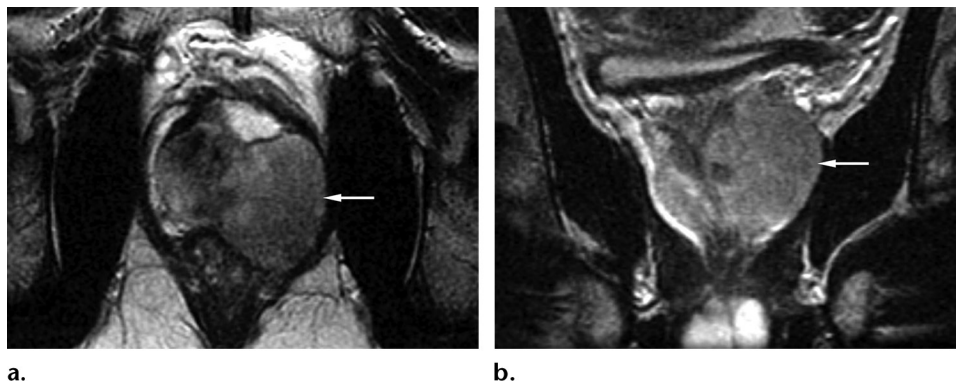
Prostatic carcinoid in a 38-year-old man with known carcinoid. A prostatic mass was identified at a posttreatment CT examination performed for restaging, and an MR imaging examination was ordered for further evaluation. Axial (a) and coronal (b) T2-weighted MR images show a large slightly heterogeneous hyperintense mass (arrow) involving the left side of the prostate from the apex to the base.
